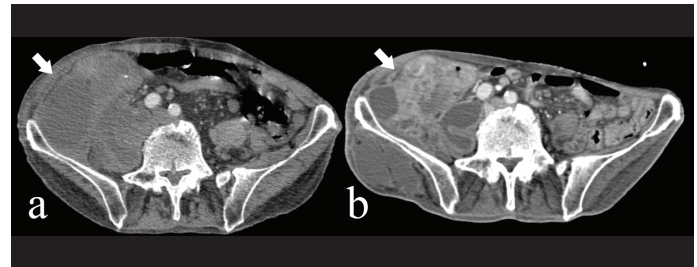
Abscess formation (arrow) on pre-interventional CT (a) and the progression in abscess volume with previously unknown cecal tumor (arrow) on post-interventional CT (b) 7 days after percutaneous drainage in 82-year-old man with perforated appendicitis.
